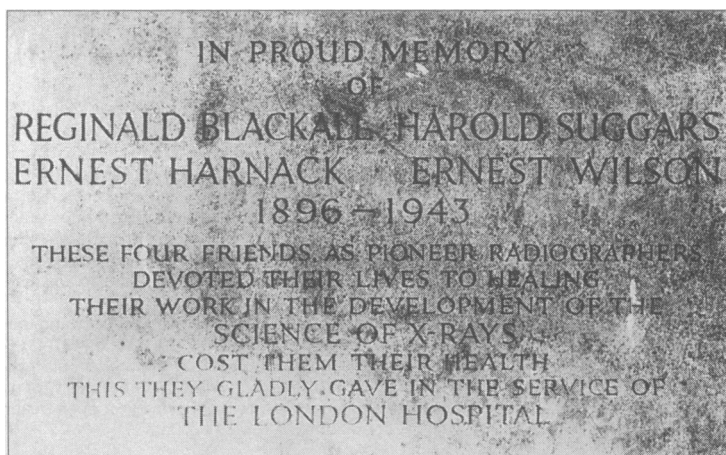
The memorial tablet to the four x-ray technicians at the London Hospital, now the Royal London Hospital, London, England, who died as a result of radiation.
